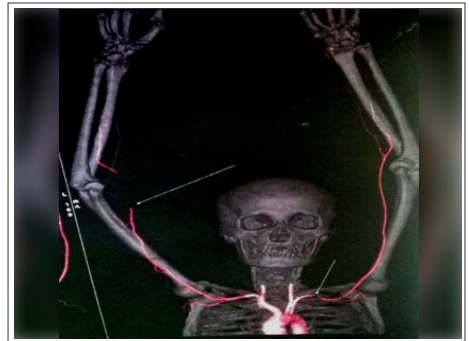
CT-angiography showing truncated brachial artery above the bifurcation (arrows) with reconstitution of distal flows by collateral branches
